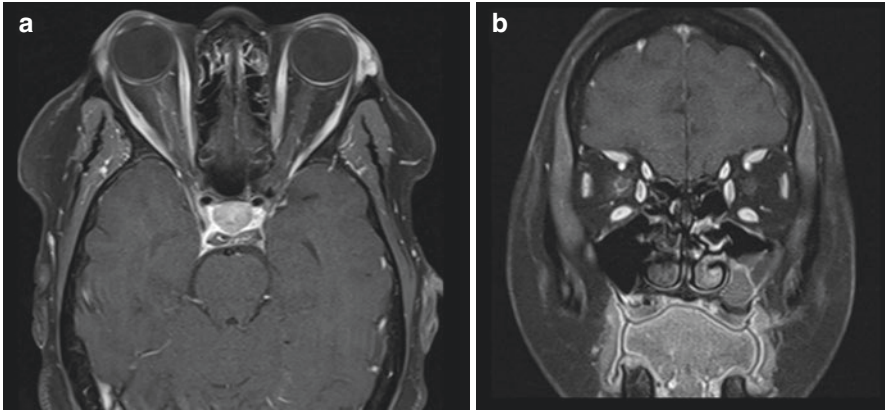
(a) Axial and (b) coronal T1-weighted post-contrast MRI demonstrates right perineural enhancement, with sparing of the optic nerve itself, in the setting of a relapse in a patient with known MOGAD (© AD Henderson 2021. All Rights Reserved)
